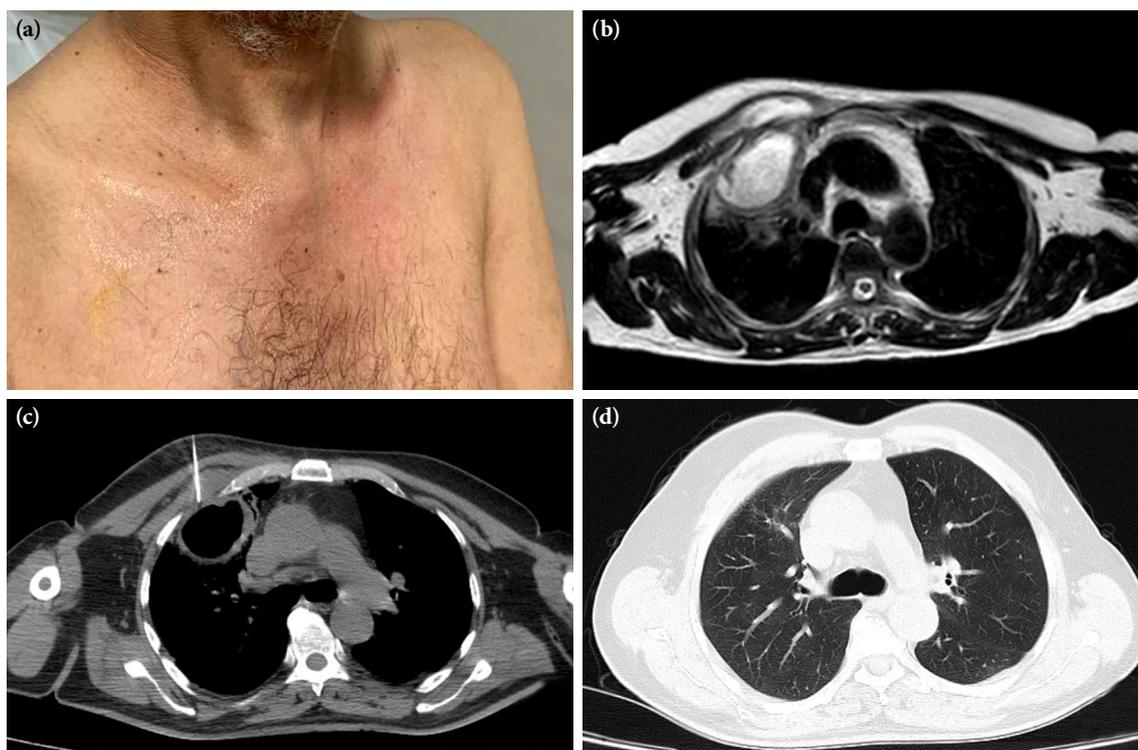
Image of the patient and imaging studies of chest wall. (a) Swelling and erythema on right costochondral joint. (b) Chest wall abscess including right sternoclavicular joint on magnetic resonance imaging (axial T2-weighted). (c) Computed tomography-guided needle aspiration of abscess. (d) Total recovery after antibiotic treatment).
